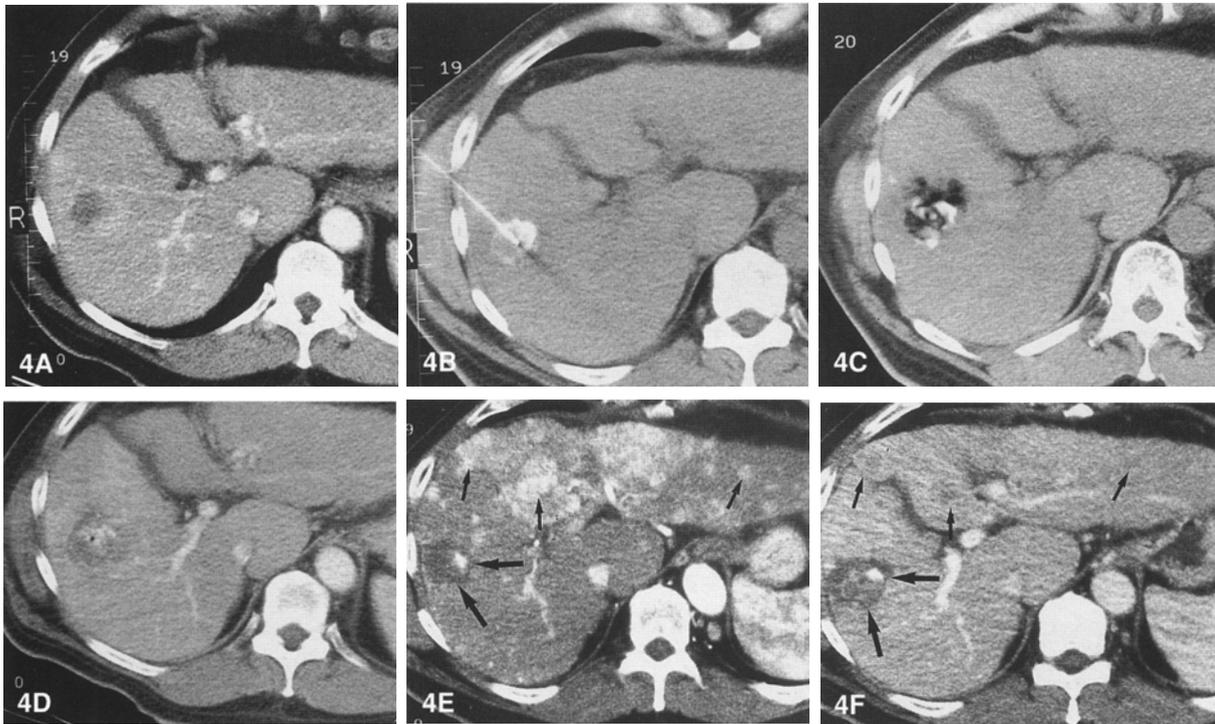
Combined treatment of HCC with chemoembolization and PEI: immediate CT findings. A Contrast-enhanced spiral CT shows a HCC with a diameter of 3 cm before treatment with chemoembolization with doxorubicin and iodized oil. B Unenhanced scan obtained 4 weeks after selective intraarterial chemoembolization and immediately before PEI. The lesion is hyperattenuating due to retention of iodized oil. C Unenhanced scan obtained immediately after PEI. A mixed-density pattern is seen owing to the hypoattenuating ethanol. D Early follow-up. Contrast-enhanced spiral CT scan obtained for follow-up several days after PEI. The hypoattenuating areas have disappeared, but some residual hyperattenuating areas due
